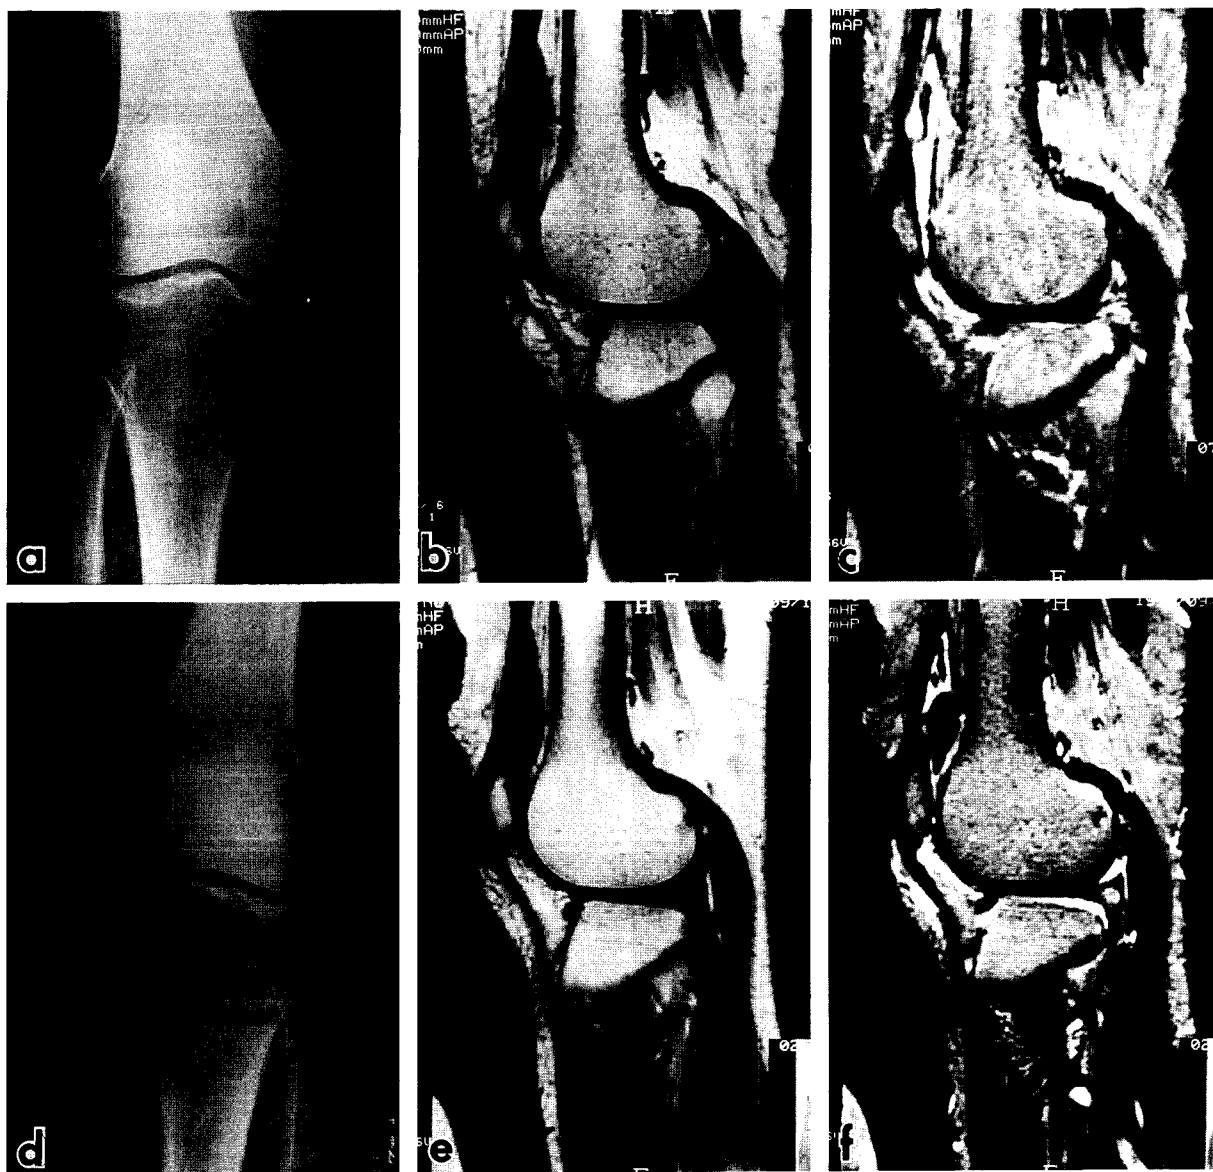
The case of a 63-year-old woman who has been suffered from RA for one year and seven months. a, b, c: Left knee; d, e, f: Right knee; a, d: Radiograph; b, c, e, f: MRI; b, e: T1-weighted image (T1WI); Reverse time/Echo time (TR/TE) = 500/20ms; c, f: T2-weighted image (T2WI); TR/TE = 2300/100ms.
